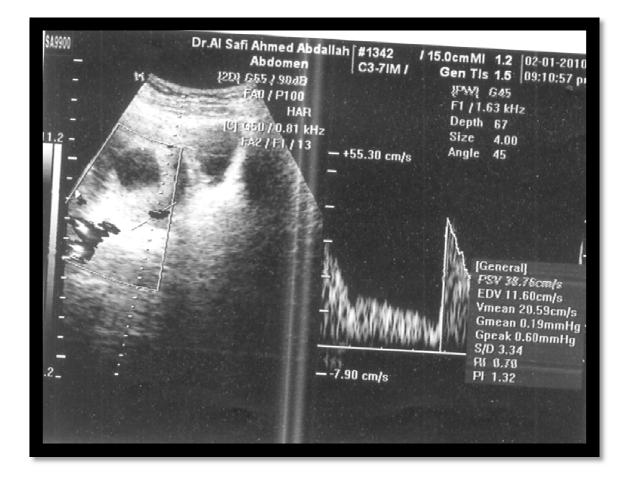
30 old patient has a history of (RPL) the abdominal Sagittal color Doppler scan Showing a Blighted ovum pregnancy.
